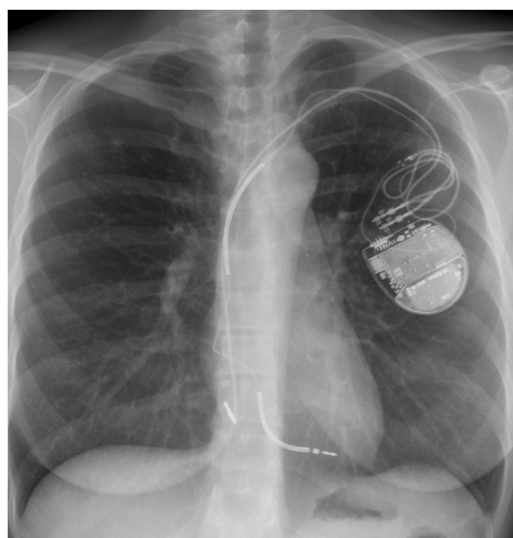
Chest radiograph shows left pectoral device location with adequate positioning of the atrial lead in an anterolateral position and of the ventricular lead in an apical-septal position. There is no evidence of lead fracture or insulation defects.
